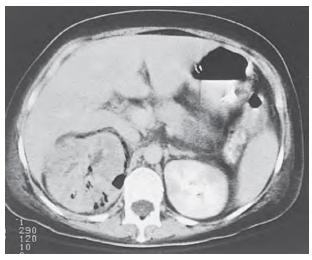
Emphysematous pyelonephritis in a patient with diabetes. This computed tomography scan shows an enlarged, inflamed right kidney with air in the parenchyma and subcapsular space. (*Courtesy Dr. M. Bergeron.*)
